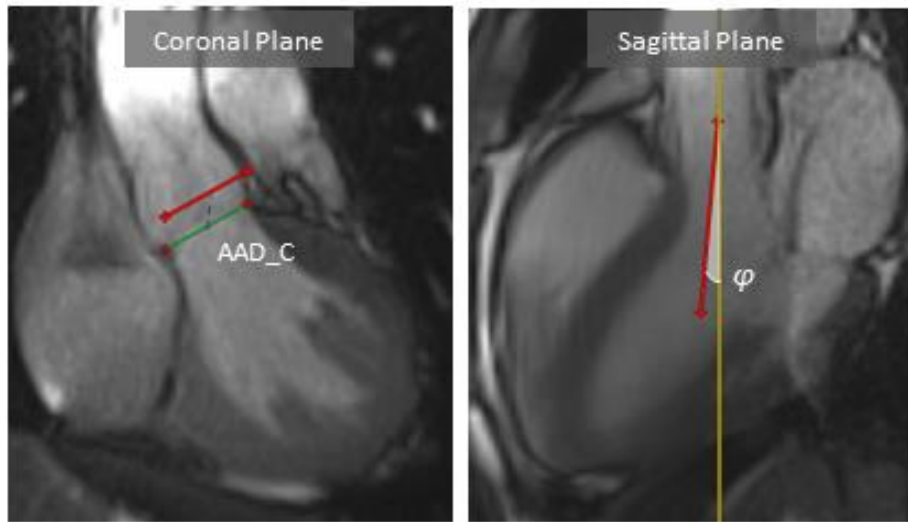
3 Motion of the aortic root in 2 planes. (left) Coronal cine-MR images showing the position of the ventriculo-aortic junction (VAJ) in systole (green line) and in diastole (red line). The blue dotted line represents the maximal aortic annulus displacement in the coronal plane (AAD_C) linking the mid-points of the VAJ in systole and diastole. (right) Sagittal cine-MRI images depicting the motion vector in the sagittal plane (red arrow) and the cross-reference line (yellow line). The angle, ϕ , between the red vector and yellow line represents the angle of rotation between the two planes. The total displacement from diastole to systole was calculated as $AAD_C \cdot \cos(\phi)$ and was found equal to 9.5 mm
